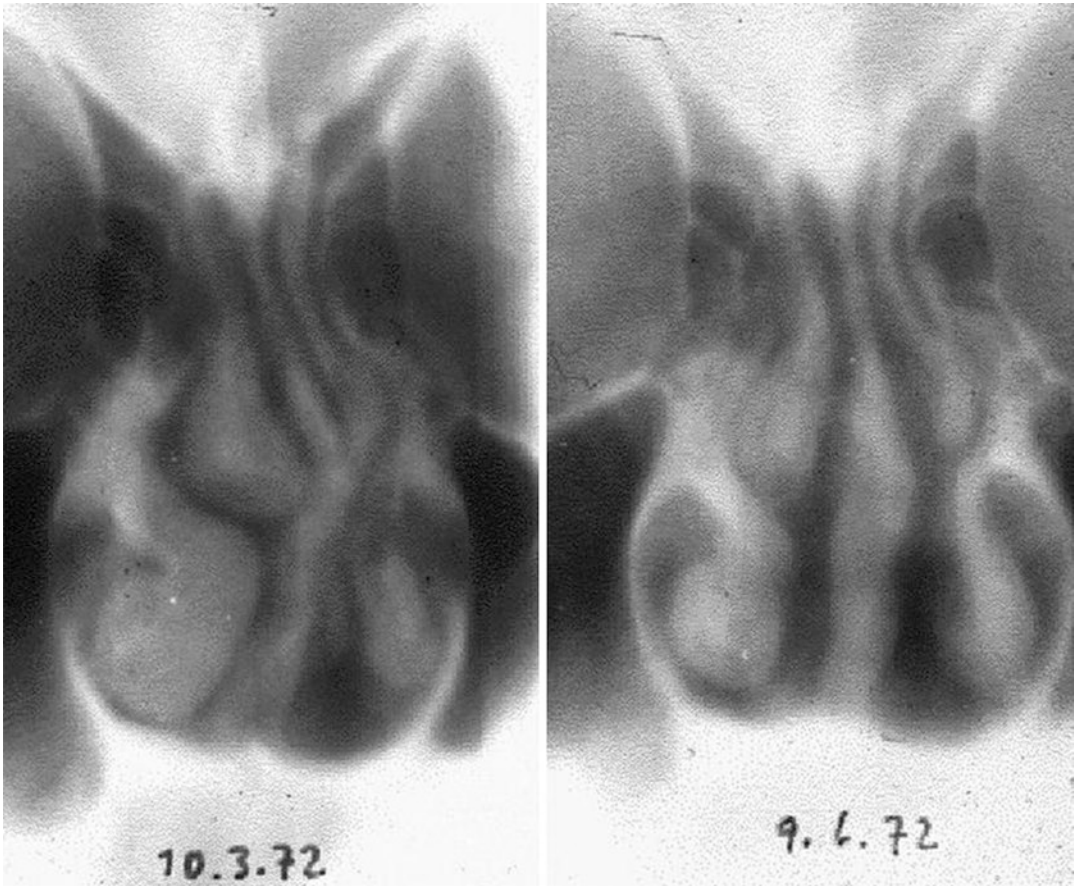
X-ray images of a patient with septal deviation. *Left:* preoperatively. *Right:* 3 months after septoplasty and correction of the right-sided middle and inferior
